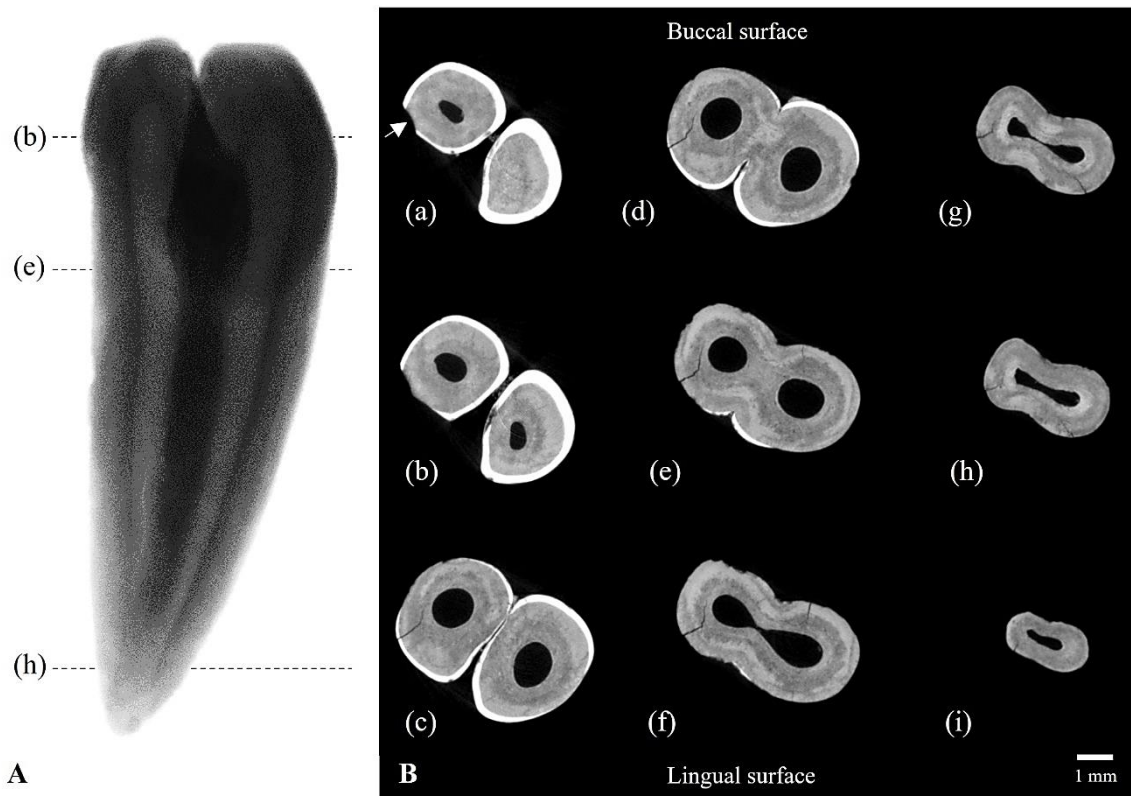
X-ray of primary maxillary teeth of Macael Viejo showing the partial fusion of crowns and roots.
